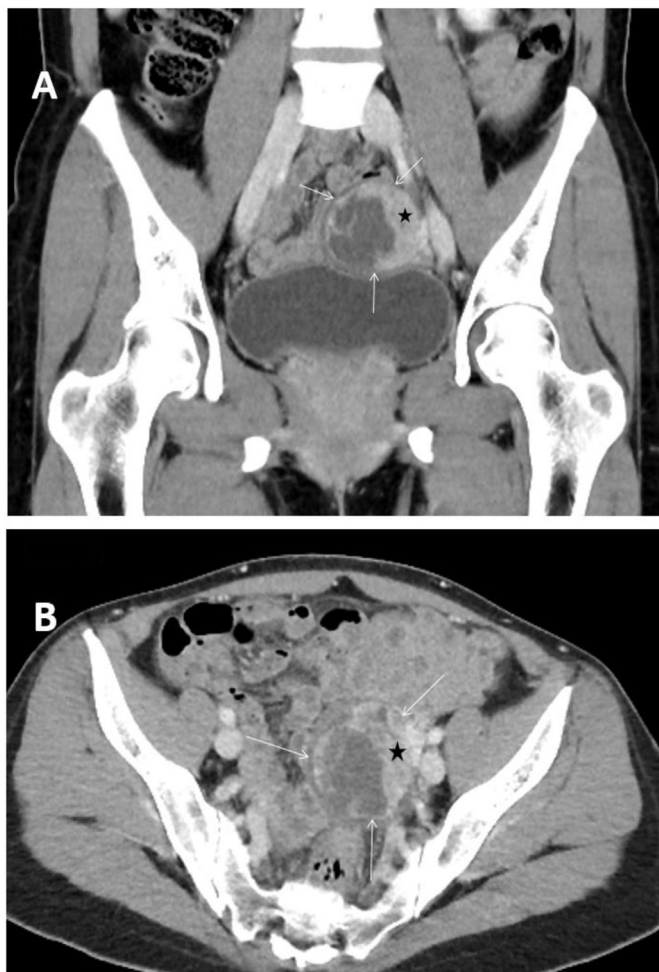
Contrast enhanced computed tomography: An axial scan in (A) and a coronal reconstruction imaging (B) show a complex cystic lesion (white arrows) with an enhancing soft tissue part in left pelvic cavity, in favor of tumor growth.
